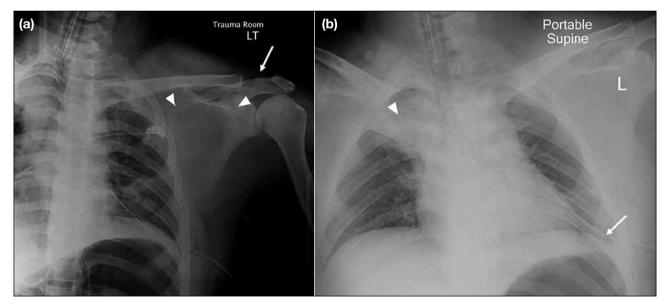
A 23-year-old motorcyclist had a road traffic accident and was found unconscious by the accident and emergency department. (a) Initial anteroposterior left shoulder radiograph revealed left acromioclavicular joint dislocation (arrow), and a sclerotic line over the scapula was suggestive of scapular fracture (arrowheads). (b) Portable supine anteroposterior chest radiograph post-intubation was not optimal for measurement of the scapular ratio to support a diagnosis of scapulothoracic dissociation. It showed left chest drain in-situ (arrow) with right upper zone opacification (arrowhead) due to lung contusion.
